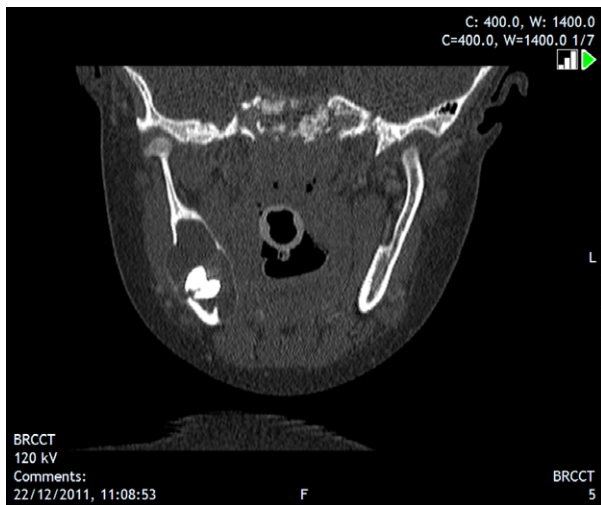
Coronal view of the pre-operative CT scan
